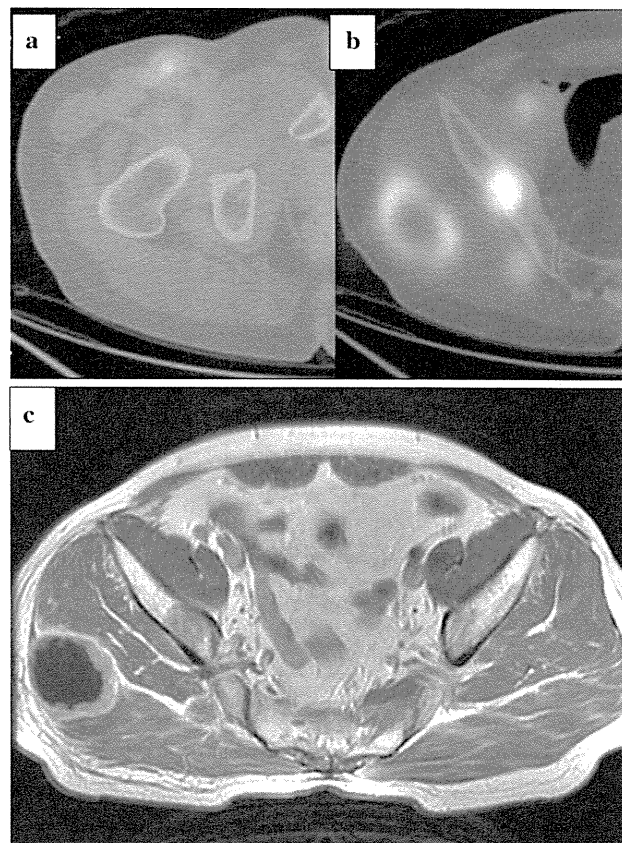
Case 1. a PET/CT shows the lymph node swelling in the right inguinal. b PET/CT demonstrates the abnormal uptakes in intrapelvic lymph node, ilium, and buttocks. c Axial T2 weighted MRI shows the bone metastases of the right ilium and soft tissue metastasis in buttock
